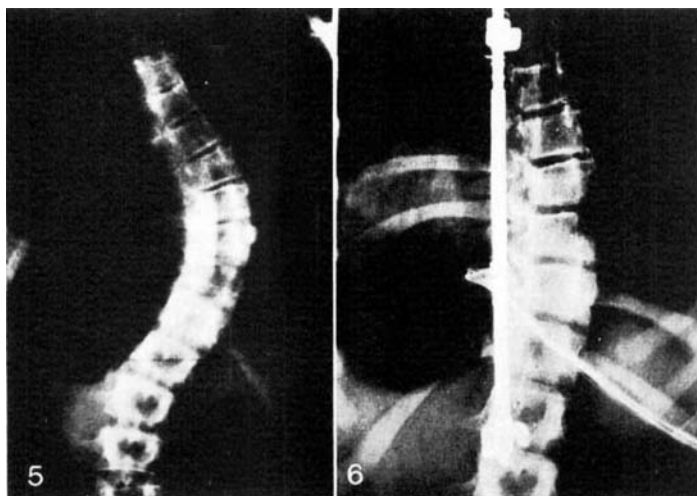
Erect roentgenogram of Patient 1.
